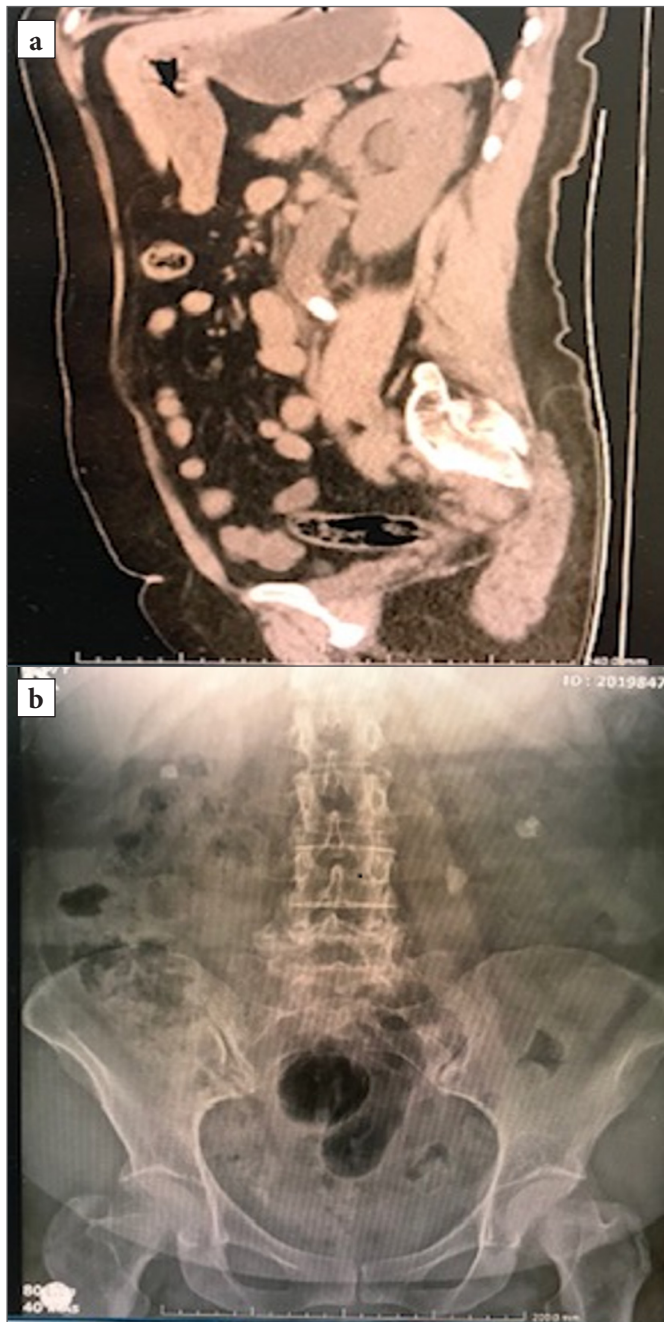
Stone status at first presentation. A left obstructed ureteral stone and bilateral renal stones is seen. a) Preoperative CT scan. b) Preoperative KUB film.
